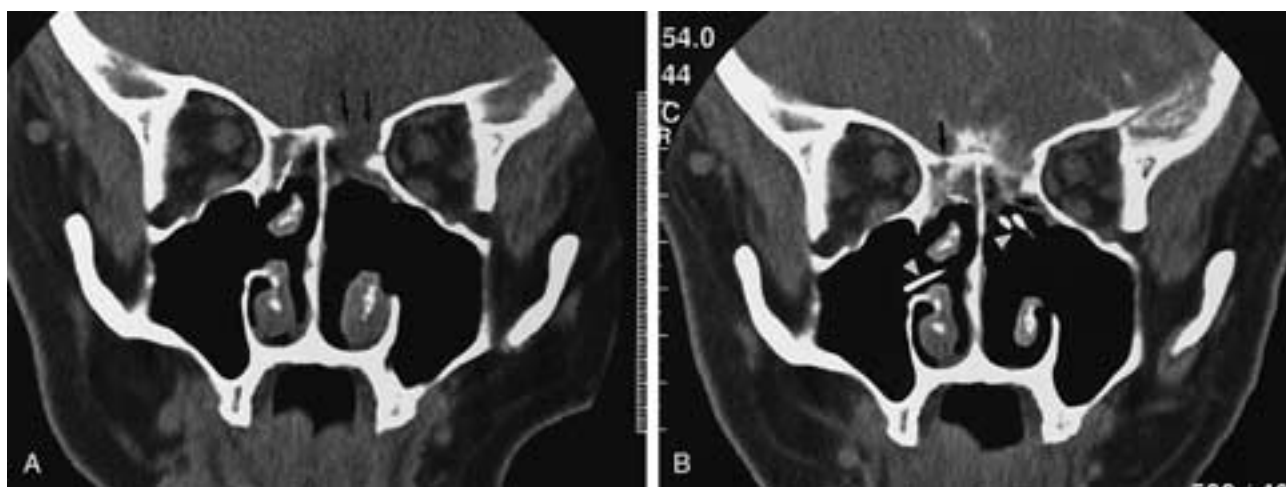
Persistent nasal discharge months after FESS. A, Precisternogram coronal CT scan, 3-mm slice thickness, intermediate window, shows obvious bony dehiscence at the posterior ethmoid roof on the left (*black arrows*). Postoperative findings include a thinned, straightened septum from prior septoplasty, widening of each maxillary sinus infundibulum including bilateral uncinectomies, complete resection of the left middle turbinate, and bilateral ethmoidectomies. There is high density within the right complex (*white arrow*), probably from osteitis. This bony sclerosis is often seen in chronic sinus inflammatory disease, especially following FESS. B, Postcisternogram coronal CT scan shows high-density nonionic contrast within the subarachnoid spaces. There is a collection of contrast within the soft tissue filling the left posterior ethmoid (*black arrow*) at the location of the bony dehiscence. Subtle contrast accumulation is also seen in the right ethmoid complex (*white arrow*) inferior to the osteitis. The smaller bony defect on the right (*long black arrow*) was not seen on the precisternogram portion of the study. Nasal pledgets, placed for the nuclear cisternogram, are seen bilaterally (*arrowheads*). These were removed at 24 hours to detect the presence of radiopharmaceutical. This additional portion of the study confirms the presence of a leak and is helpful in subtle cases. Also note that the window and level settings (window—500, level—40) are narrower than those used for screening sinus CT. The narrower settings improve visualization of contrast.
